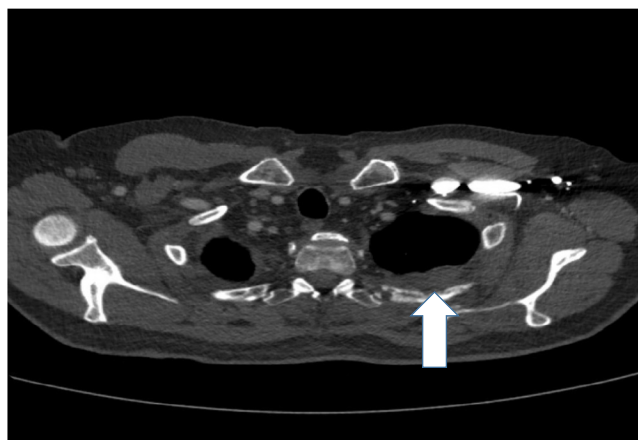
Computed tomography thorax showing obliteration by enhancing mass and loss of the cortical line in the anterior wall of the bony foramen (blue-white arrows).
